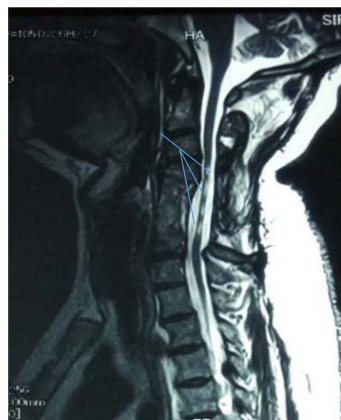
MRI of the cervical spine in T2 sequence. Intramedullary cavitation (arrow), with spinal cord deformation.
